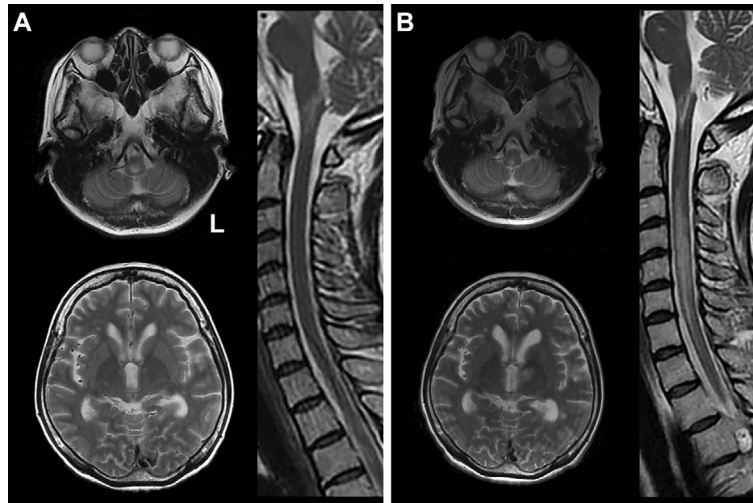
Brain MRI findings. A: Initial MRI (T2-weighted images) performed when the patient showed no hyperCKemia. Hyperintense areas were observed in the left temporal horn, left pontine tegmentum, and left medulla oblongata, whereas no abnormalities were observed in the spinal cord. B: The second MRI procedure performed when the patient showed hyperCKemia. Hyperintense areas were observed in the spinal cord extending from C2 to T1 as well as in the left thalamus and left medulla oblongata.
